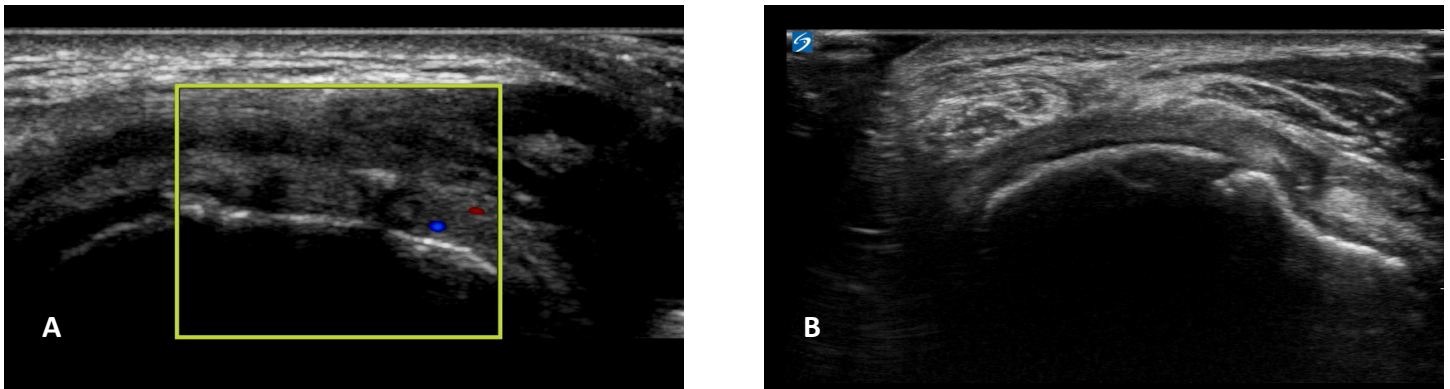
Pulsatile vessels observed in post-operative ultrasound A) 6 months B) 24 months
